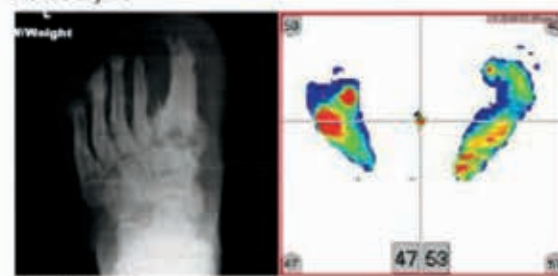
Post-operative TMA Radiographs with corresponding pressure mapping
